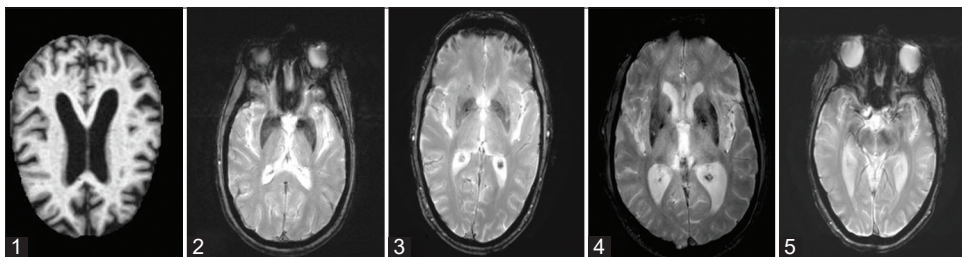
Samples of magnetic resonance imaging images representing different Alzheimer's disease (AD) stages. (1) AD, (2) Late mild cognitive impairment; (3) Mild cognitive impairment, (4) Early mild cognitive impairment, (5) Cognitively normal.
